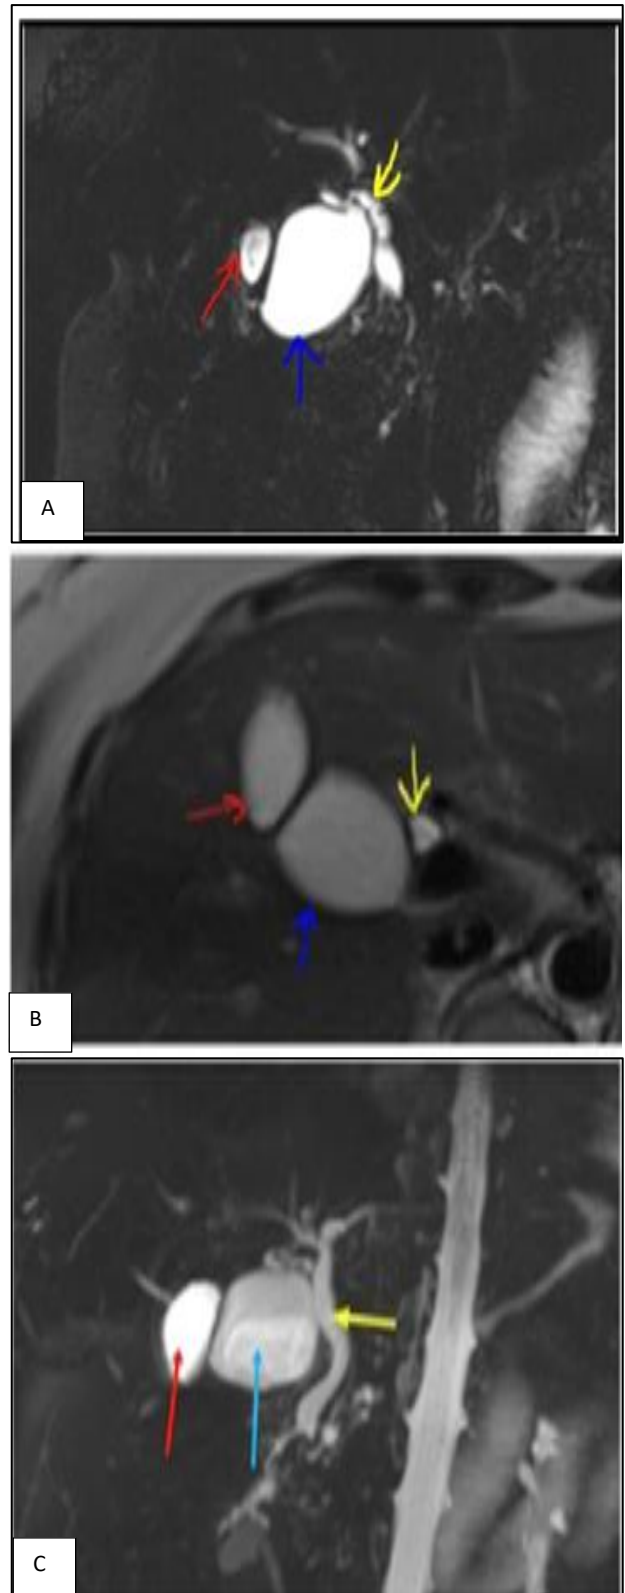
(A-C): MRI images.
